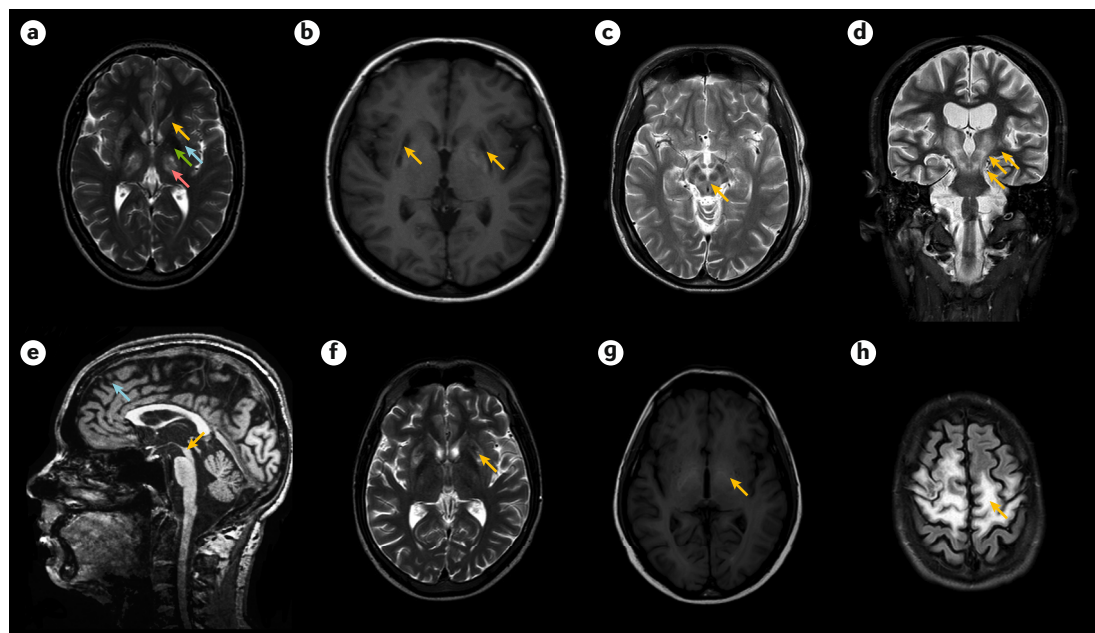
Brain MRI changes in WD. Usual abnormalities in brain MRI in patients with Wilson disease (WD) include symmetric hyperintense changes visualized in T_2 -weighted images of the basal ganglia, particularly the putamen (blue arrow), caudate nuclei (orange arrow), thalami (pink arrow) and globi pallidi (green arrow) (part a). In more advanced cases, severe tissue damage can be visualized in T_1 -weighted images as hypointensity in the putamen (part a, blue arrow; part b, orange arrows). The most spectacular changes observed in WD are described as the ‘face of the giant panda’ in the midbrain (part c, orange arrow). Another common MRI abnormality is increased T_2 signal along the dentato-rubro-thalamic pathway (part d, orange arrow), which is a major efferent pathway from the cerebellum involved in movement disorder symptoms, including ataxia, tremor and dystonia. In severe neurological WD, diffuse brain atrophy (part e) may be seen in the midbrain (orange arrow) and cortex (blue arrow). In brain MRI scans from a 21-year-old male with severe liver failure and discrete neurological signs, hyperintense changes in putamina can be visualized in T_2 -weighted images, which is characteristic of early stages of brain involvement (part f, orange arrow). Hyperintense changes in the globi pallidi in T_1 -weighted images in the same patient are presumably due to manganese accumulation, which is characteristic of hepatic encephalopathy (part g, orange arrow). Very rarely, diffuse white matter changes in both brain hemispheres are observed with preservation of the cortex, probably due to myelin destruction (part h, orange arrow).
